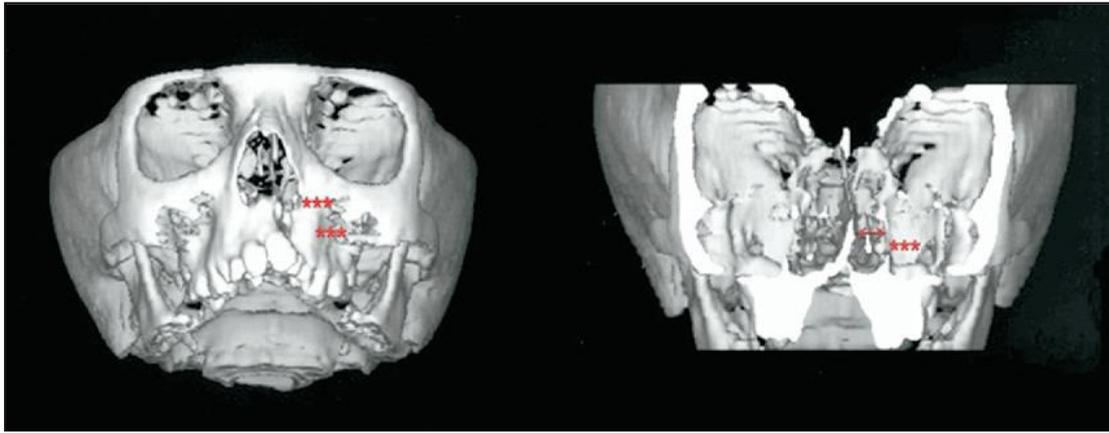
3D reconstruction using CT (Source: Suri S, Utreja A, Khandelwal N, Mago SK. Craniofacial computerized tomography analysis of the midface of patients with repaired complete unilateral cleft lip and palate. *Am J Orthod Dentofac Orthop.* 2008;134:418-29.)
